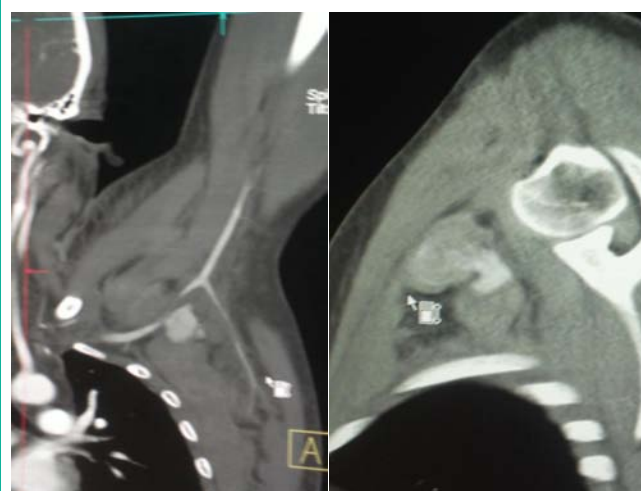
CT angiography showing subclavian artery pseudoaneurysm with openings in subclavian artery.
